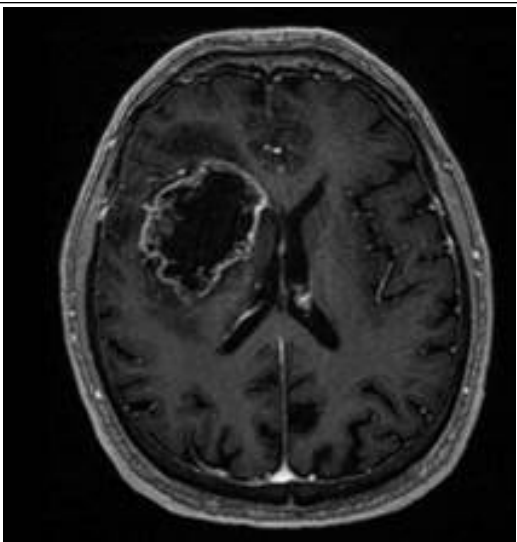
Contrasted T1 MRI of 84 year old male who presented with gait imbalance and left hemiparesis. Visualized is a right frontal enhancing lesion with necrotic core.
